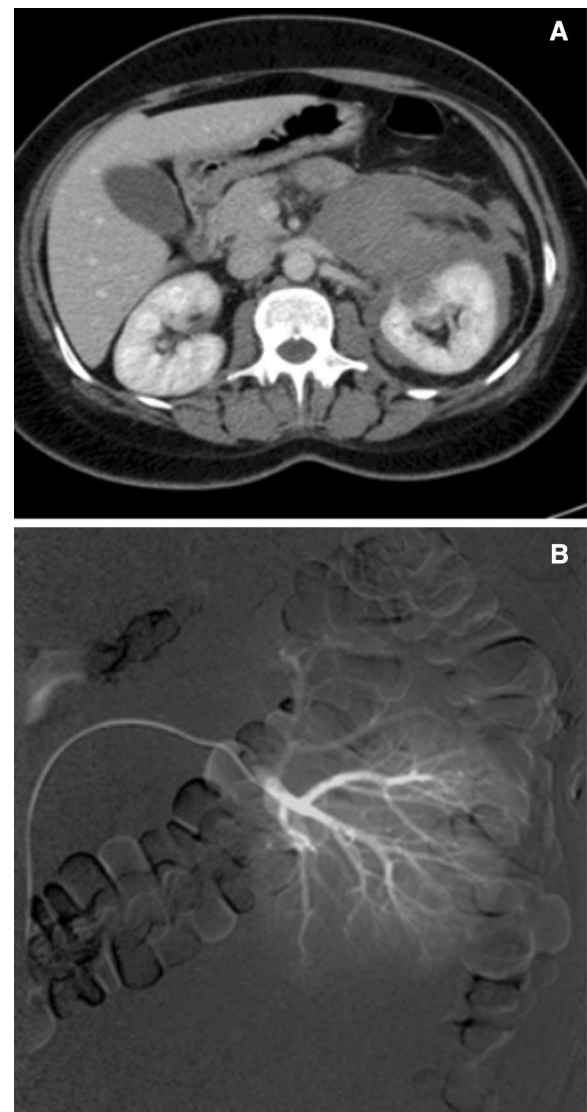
Axial non-contrast computed tomography imaging of a 45-year-old male patient with a perinephric haematoma after percutaneous nephrolithotomy showing a large perinephric haematoma related to the left renal upper pole associated with parenchymal laceration (A). Selective left renal angiography using a cobra head catheter revealed normal intrarenal arteries with no vascular lesions (B)
